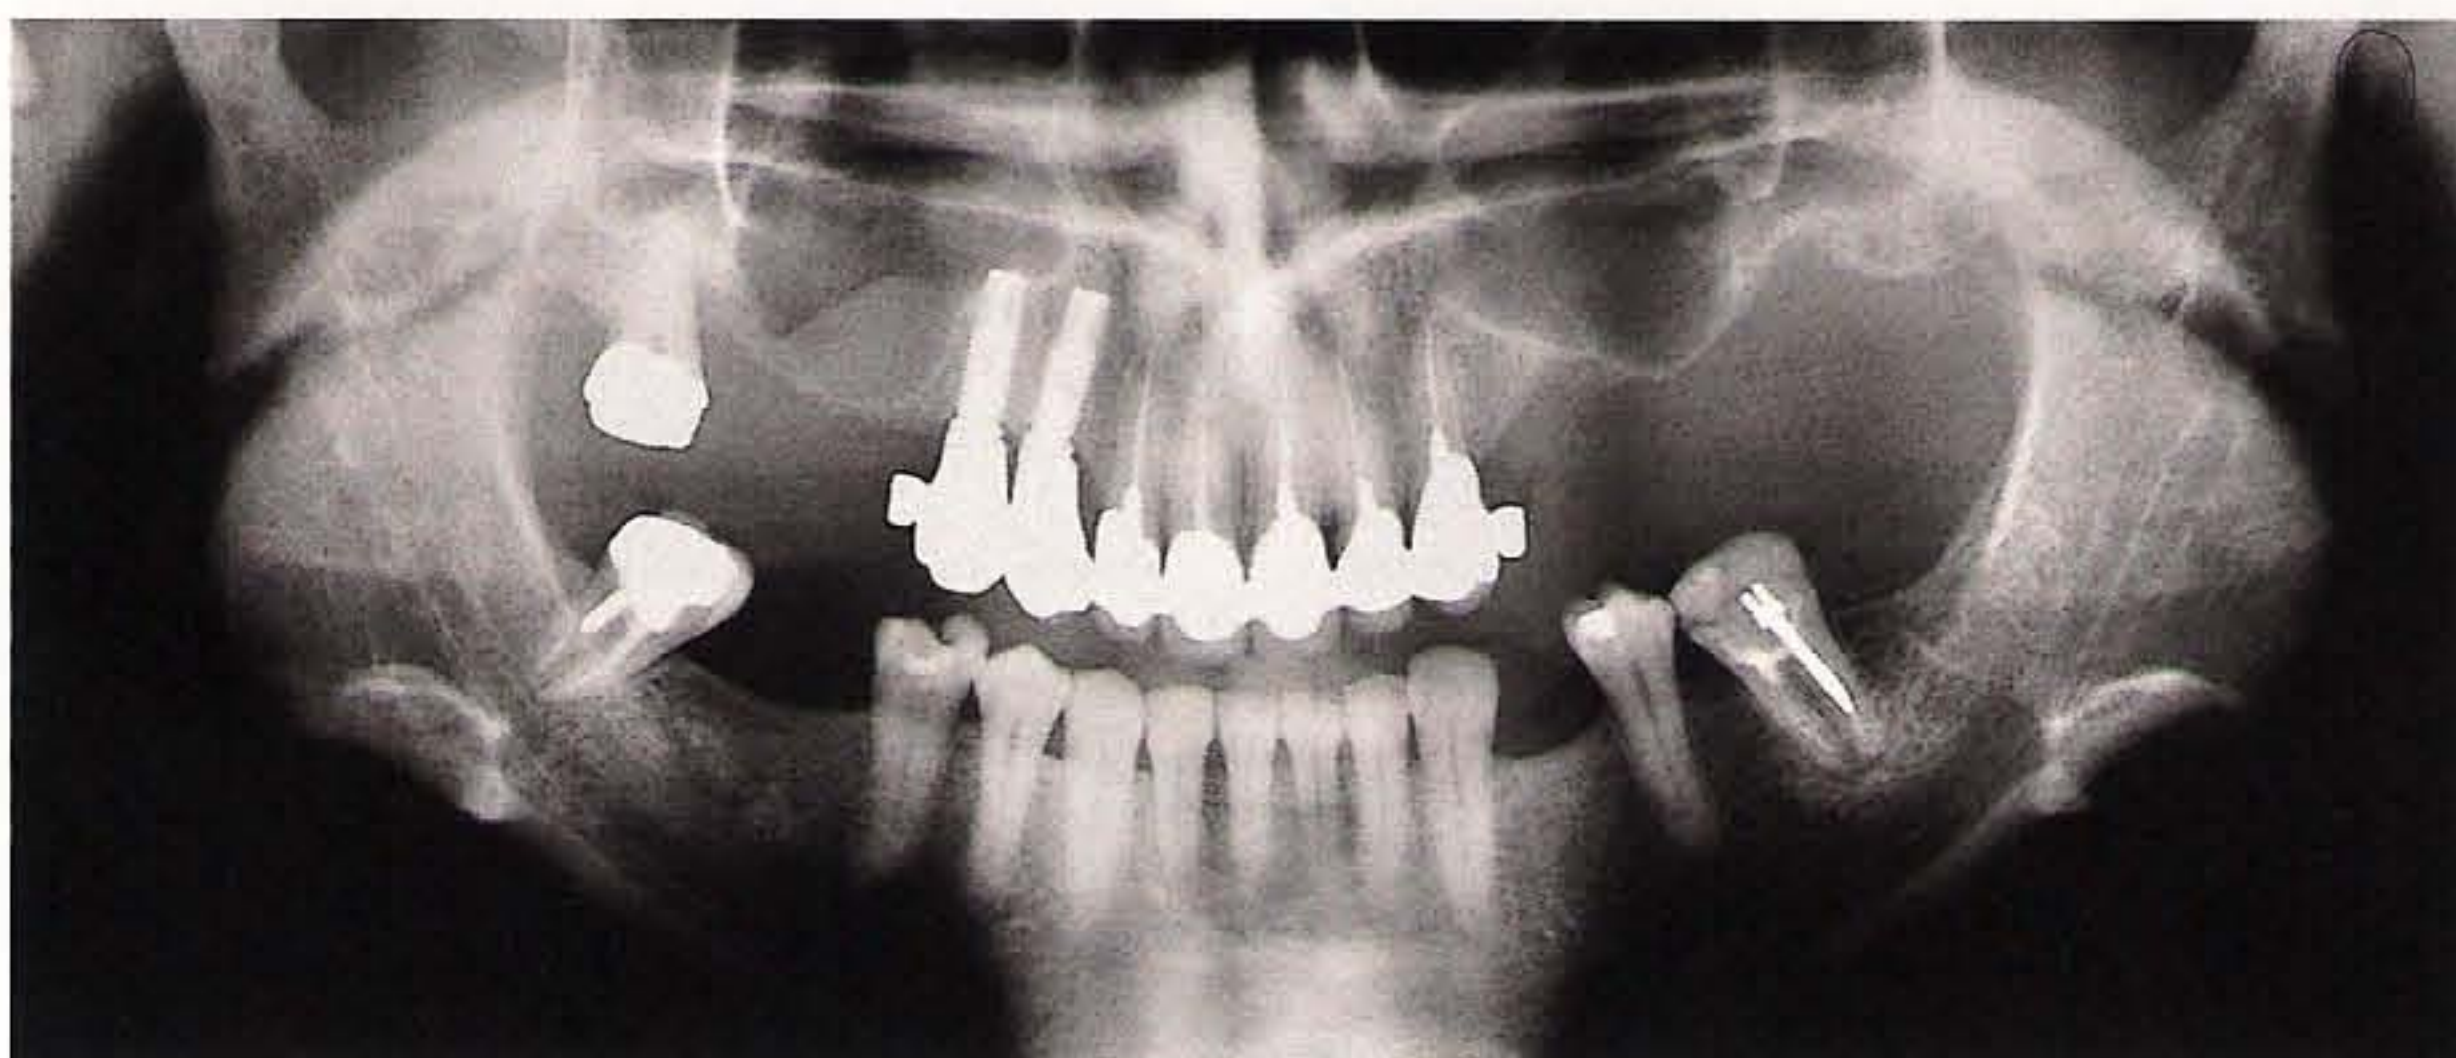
Final panoramic radiograph control.
